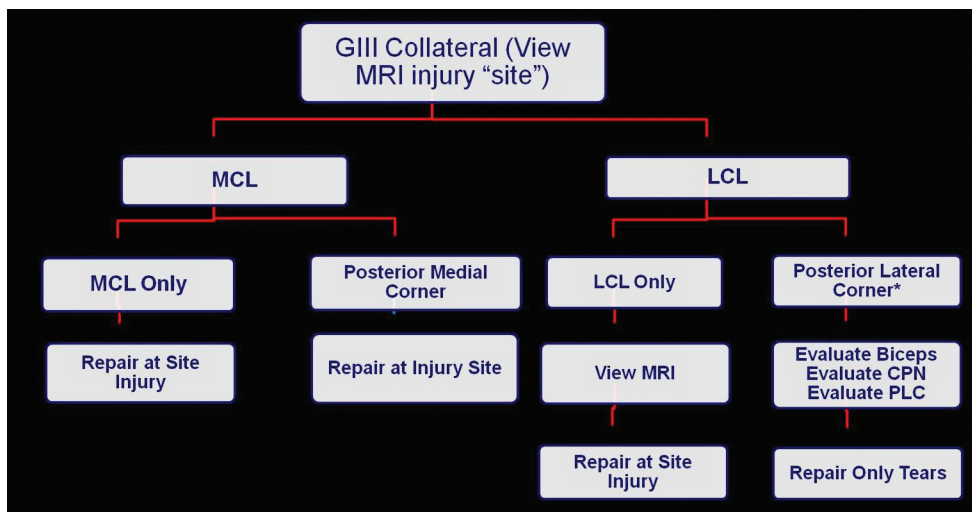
Surgical algorithm is shown for the patient that presents with complete collateral ligament injury with excessive laxity at full extension indicating associated cruciate injury. MRI – magnetic resonance imaging, MCL – medial collateral ligament, LCL – lateral collateral ligament, GIII – grade III, CPN – common peroneal nerve, PLC – posterolateral corner
